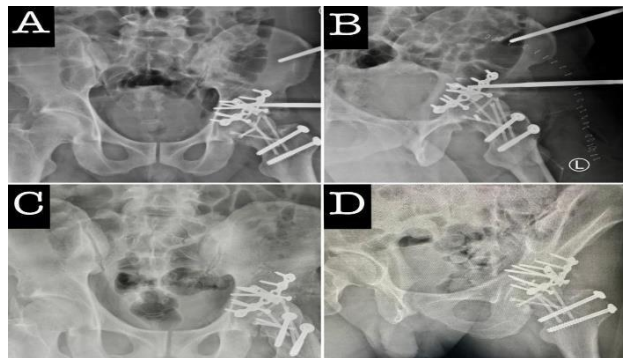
(A and B) Postoperative x-ray images. (C and D) X-ray images 2 months post external fixation removal.
